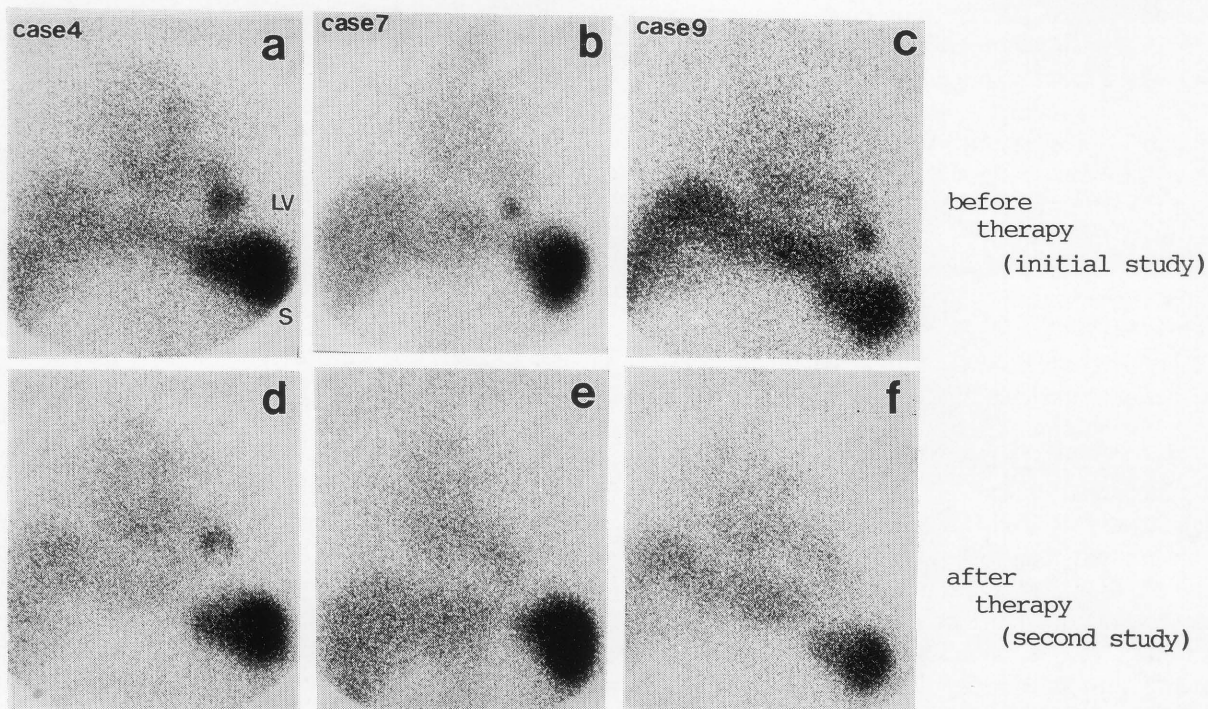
Indium-111-labeled scintigrams (Cases of 4, 7 and 9). After antiplatelet therapy, indium-111 activity within LVA (panels: a, b and c) showed a marked decrease compared with that of scintigrams (panels: d, e and f) obtained before the therapy. L: Liver, S: Spleen, LV: Left ventricle.
